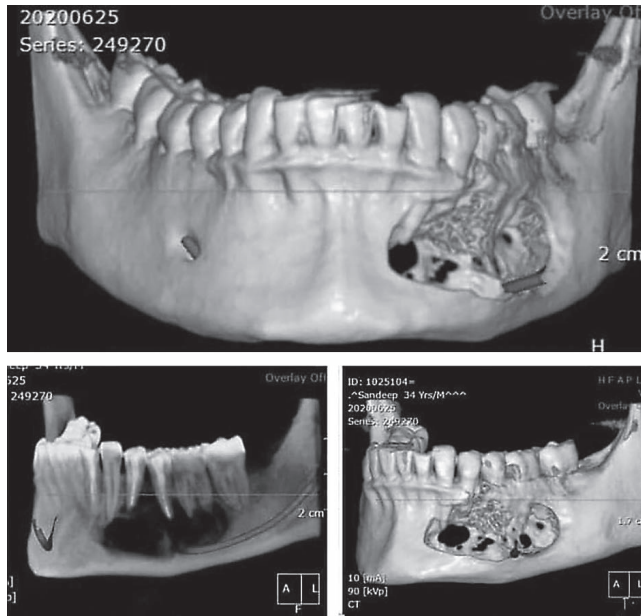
3D cone beam computed tomographic image exhibits perforations of buccal and lingual cortical plates.
